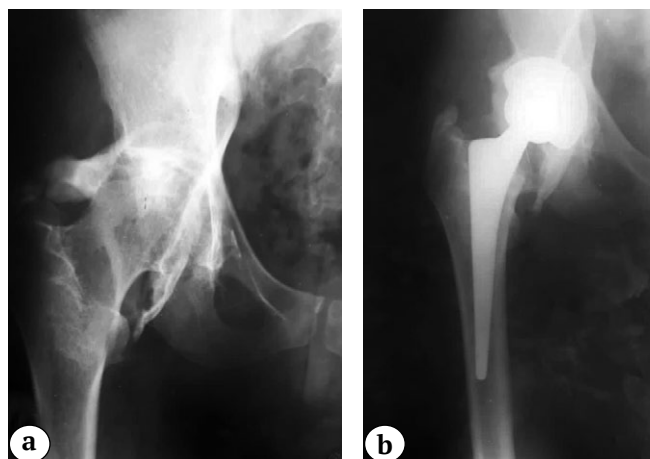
X-rays of the right hip joint: a — before the first total hip arthroplasty; b — after surgery
